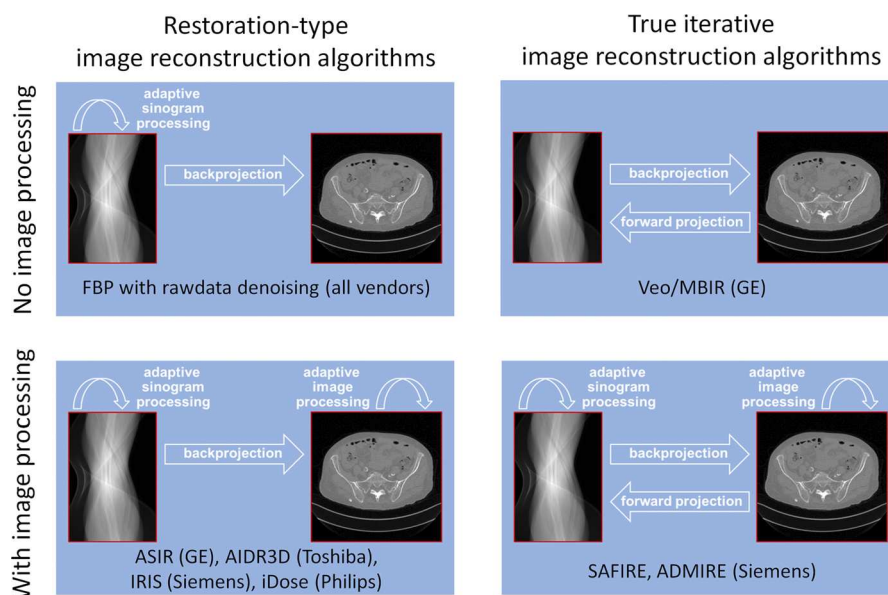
Classification of image reconstruction algorithms provided by the vendors (adapted from Kachelrieß⁹⁵). The algorithms are mostly a black box to the scientific community and users of the CT systems, with few details published. Two algorithms cannot be classified because the corresponding vendors do not disclose sufficient information (IMR [Philips], ASIR-V [GE]). Figure 4 can be viewed online in color at www.investigativeradiology.com.
